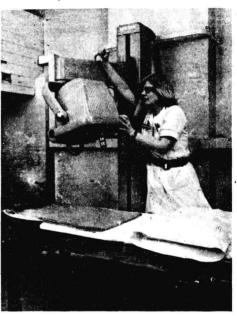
Deep X-ray therapy unit.
